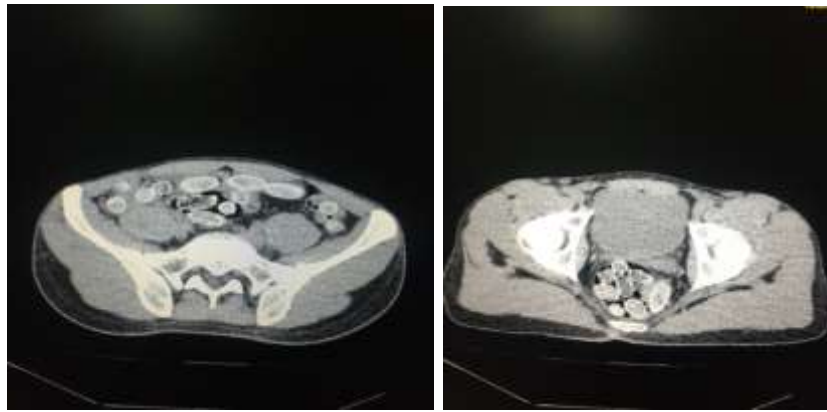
CT image showing spontaneously hyperdense ovoid intra-gastrointestinal foreign bodies in association with capsules
